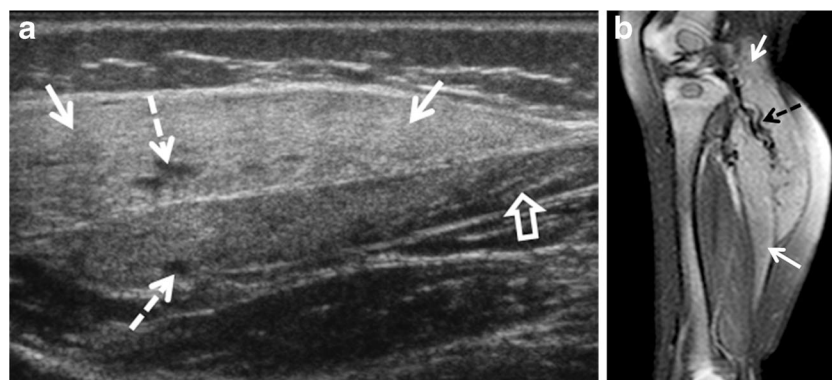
Longitudinal US (a) and sagittal fat-suppressed T2-weighted MR (b) images through the lower leg of a 5-month-old girl. The majority of the gastrocnemius and soleus muscles (solid arrows) are infiltrated and expanded by an echogenic (a) and hyperintense (b) lesion. Relative
